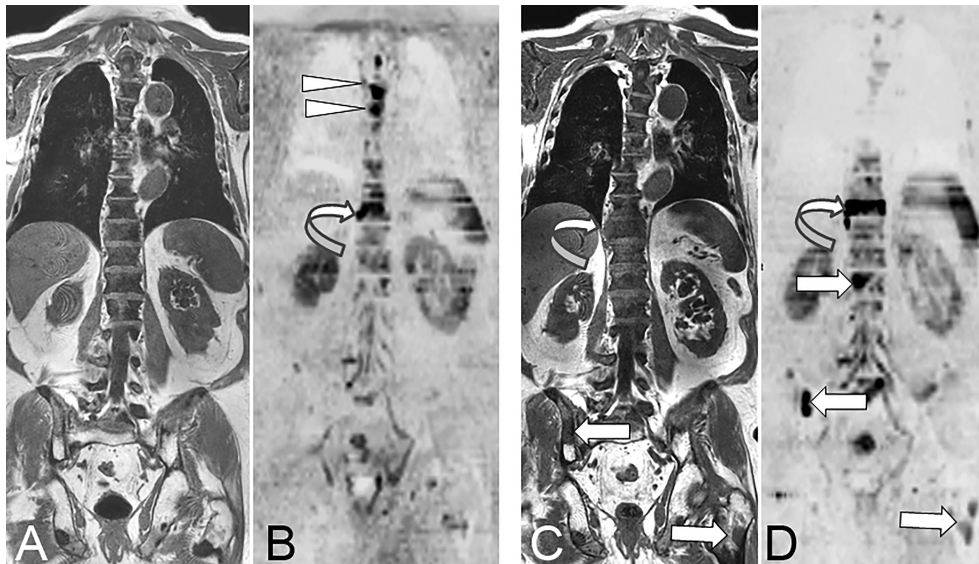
73 year-old man with advanced prostate cancer. Comparison of pre- and post-treatment (enzalutamide) WB-MRI/DWI. Baseline coronal T1-weighted MR image (A) shows diffuse bone marrow infiltration within the spine, responsible for diffuse low signal intensity of the bone marrow, and related to advanced metastatic disease after several lines of treatment. The pelvic bones show higher signal of the bone marrow indicating a fatty content due to previous irradiation. Several focal lesions of low signal intensity are visible within the pelvis and left proximal femur. Baseline DWI MR image (B; $B = 1000 \text{ s/mm}^2$, inverted grey scale) shows high signal intensity foci typical for active bone metastases within the T4, T5 (arrowheads) and T10 (curved arrow) vertebrae. Follow-up T1-weighted MR image (C) shows no evident change of the spinal bone marrow, but increase in the right paraspinal extension of the T10 metastasis (curved arrow), and a new lesion within the right posterior iliac crest (arrow). Follow-up DWI MR image (D) shows disappearance of the midthoracic vertebral lesions, but increase in size and right paraspinal extension of the T10 vertebral lesion (curved arrow), and appearance of new lesions within the L1 vertebral body, the right iliac crest and left proximal femur (arrows). The observation of concurrent signs of disease response and progression is frequent, especially in advanced stages of metastatic cancer.
